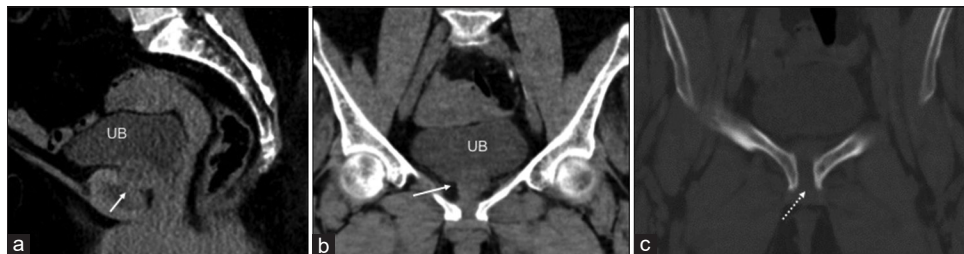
(a and b) Pelvis CT in sagittal and coronal sections show a well-defined isodense lesion (white arrow) in the space of Retzius (prevesical space) indenting the bladder neck. (c). Coronal section in bone window shows pubic diastasis and absent bony erosions (dotted arrow). UB: Urinary bladder.
